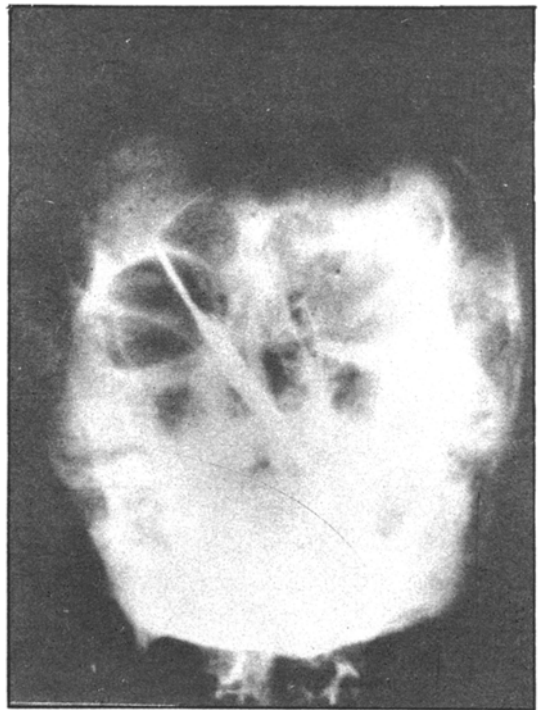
X-ray P. N. S., O. M. View showing the radio-opaque foreign body
